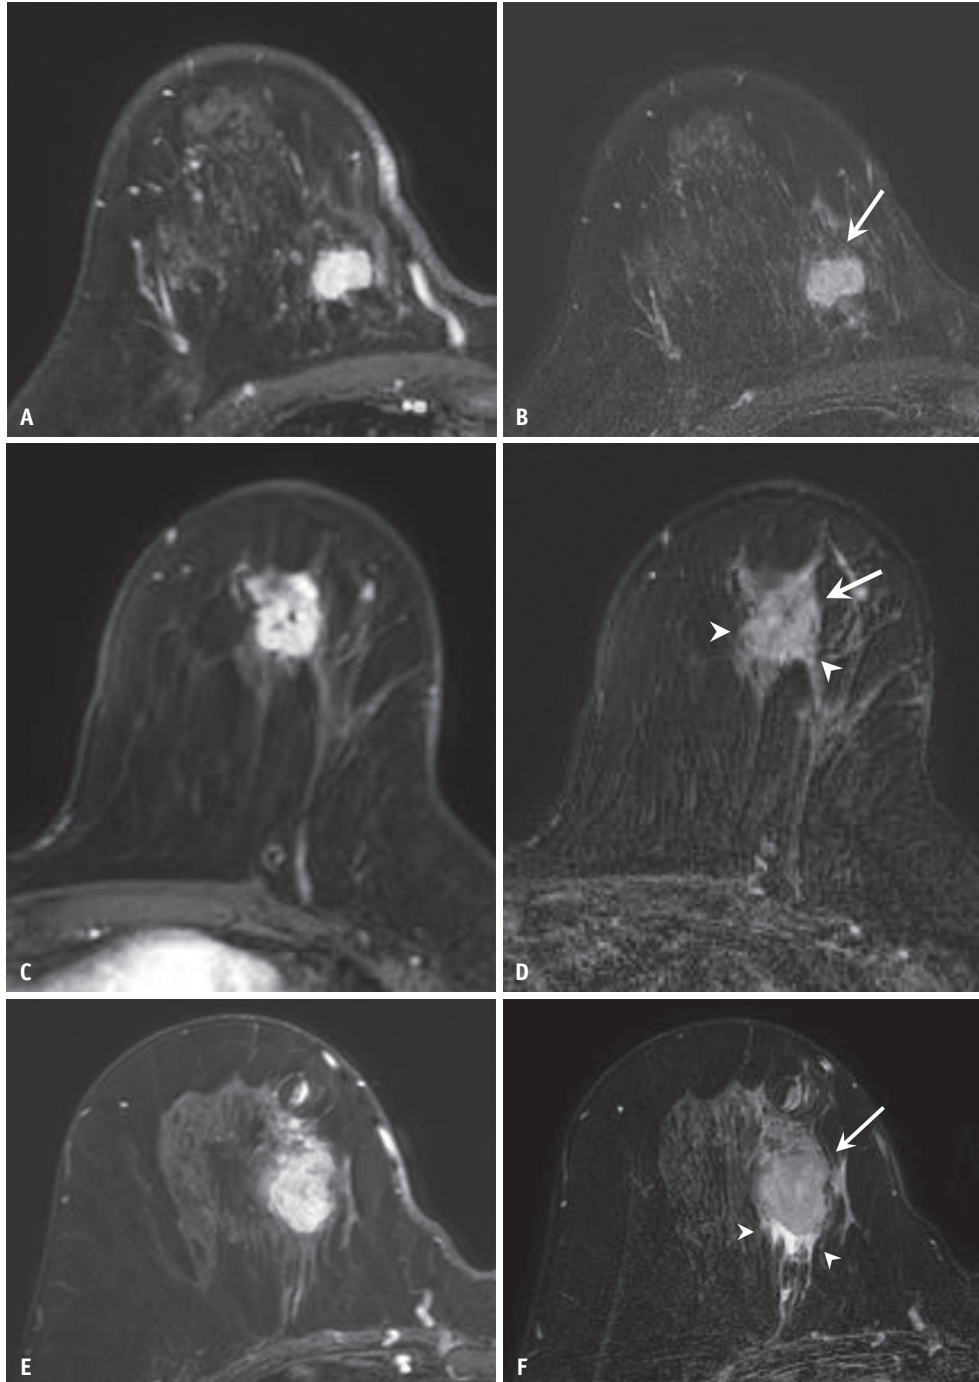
Examples of peritumoral edema grades. A, B: Fat-suppressed T1-weighted early contrast-enhanced (A) and T2-weighted axial breast MR (B) images show the absence of high T2 signal intensity surrounding the tumor (arrow) (grade 0). C, D: Fat-suppressed T1-weighted early contrast-enhanced (C) and T2-weighted axial breast MR (D) images show moderately high T2 signal intensity surrounding the tumor (arrow) on (D), which is lower than that of water (arrowheads) (grade 1). E, F: Fat-suppressed T1-weighted early contrast-enhanced (E) and T2-weighted axial breast MR (F) images show T2 signal intensity surrounding the tumor (arrow) as high as that of water (arrowheads) (grade 2).
